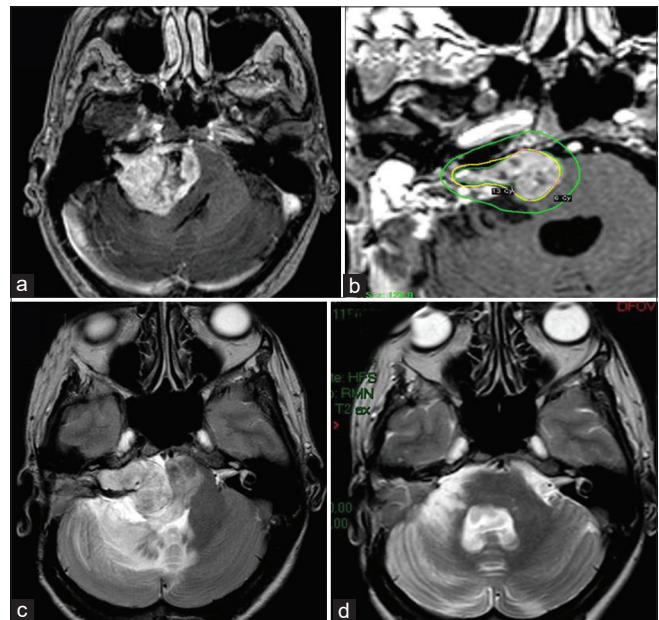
Right vestibular schwannoma with maximum diameter of 41 × 35 × 35mm. MRI T1 contrast-enhanced image before first surgery (a). MRI T1 contrast-enhanced image of Gamma Knife Radiosurgery (GKR) treatment planning (b). MRI T2 image at 18 months after GKR (c); peritumoral brain edema (PTBE) in the right cerebellar hemisphere and brain stem is clearly visible. MRI T2 at image 3 months after surgical removal showing complete PTBE resolution (d).
